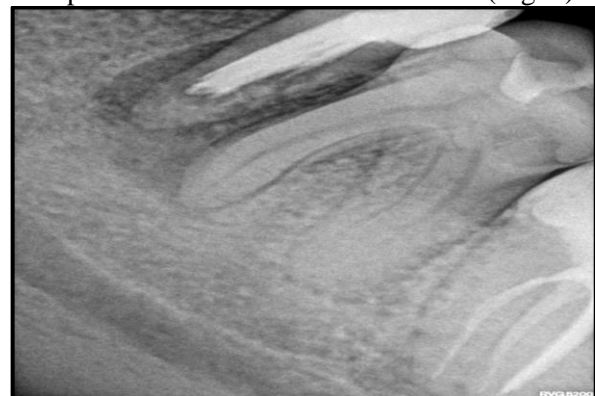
Preoperative periapical radiograph of left side mandibular second premolar
